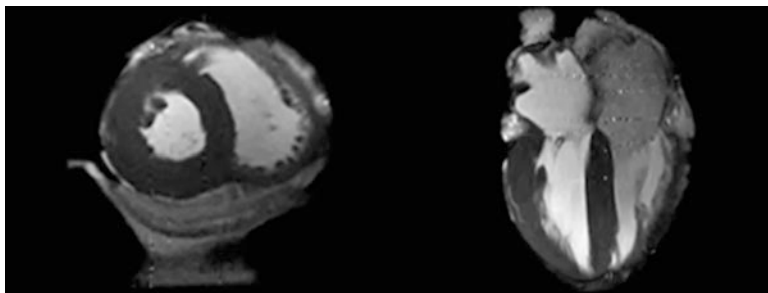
MRI images obtained from a reanimated human heart placed in a 1.5T MRI scanner: short-axis view (left) and long-axis view (right)
